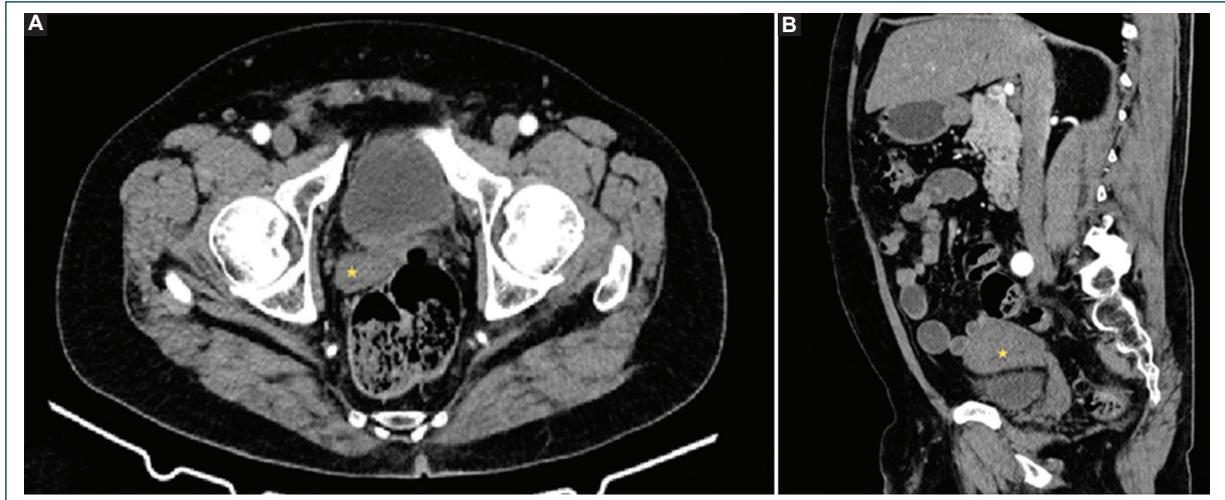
Contrast abdominal computed tomography in arterial phase in axial and sagittal planes A and B: respectively showing evidence of muscular soft tissue density mass (30 HU) in retrovesical space in contact with pelvic structures (yellow star).
